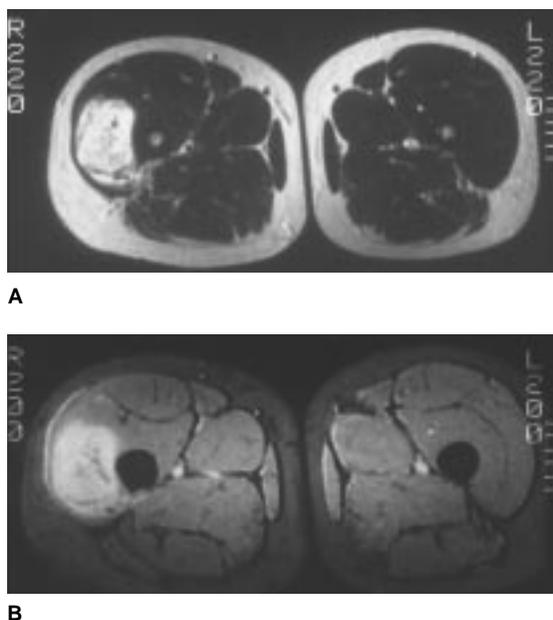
Inhomogeneous mass seen in the vastus lateralis on T1-weighted (A) and gradient-echo (B) MR images suggests presence of a malignant neoplasm.
